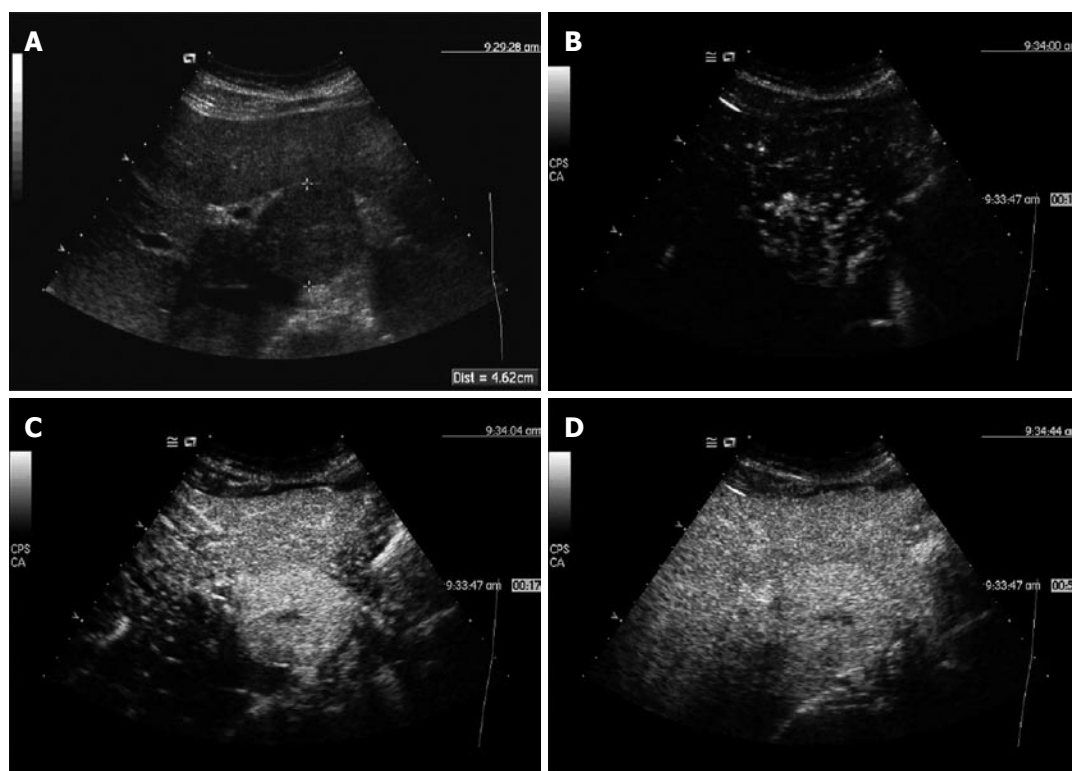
45-year-old female patient. A: 4.6 cm isoechoic lesion in segment 1 found in B-Mode sonography; B: Contrast-enhanced sonography with SonoVue® showed an early arterial enhancement with radial intratumoral vessels seen 13 s after injection; C: Strong enhancement of the whole lesion after 17 s, with a central scar becoming visible; D: In the portal phase, the lesion becomes isoechoic with the surrounding normal liver tissue. The enhancement pattern is typical for a focal nodular hyperplasia (FNH).
